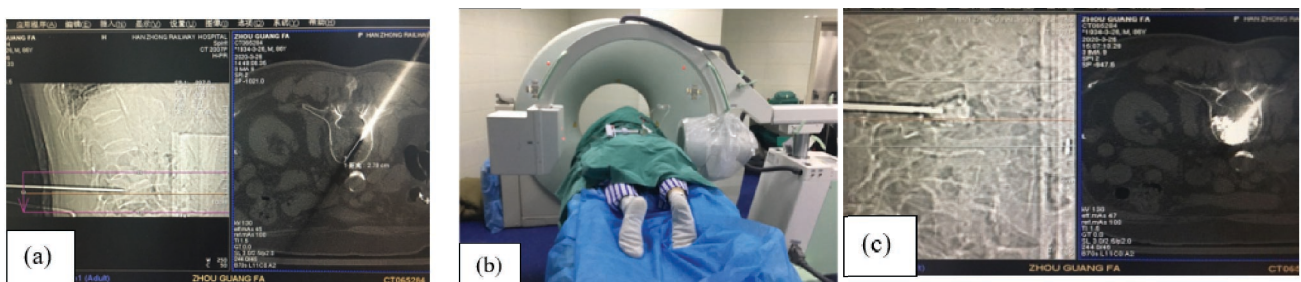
Intraoperative and postoperative pictures (a) Intraoperative CT scanning to verify the puncture route (b) Cement injection under C-arm monitoring (c) Satisfactory cement distribution observed on postoperative CT scanning
